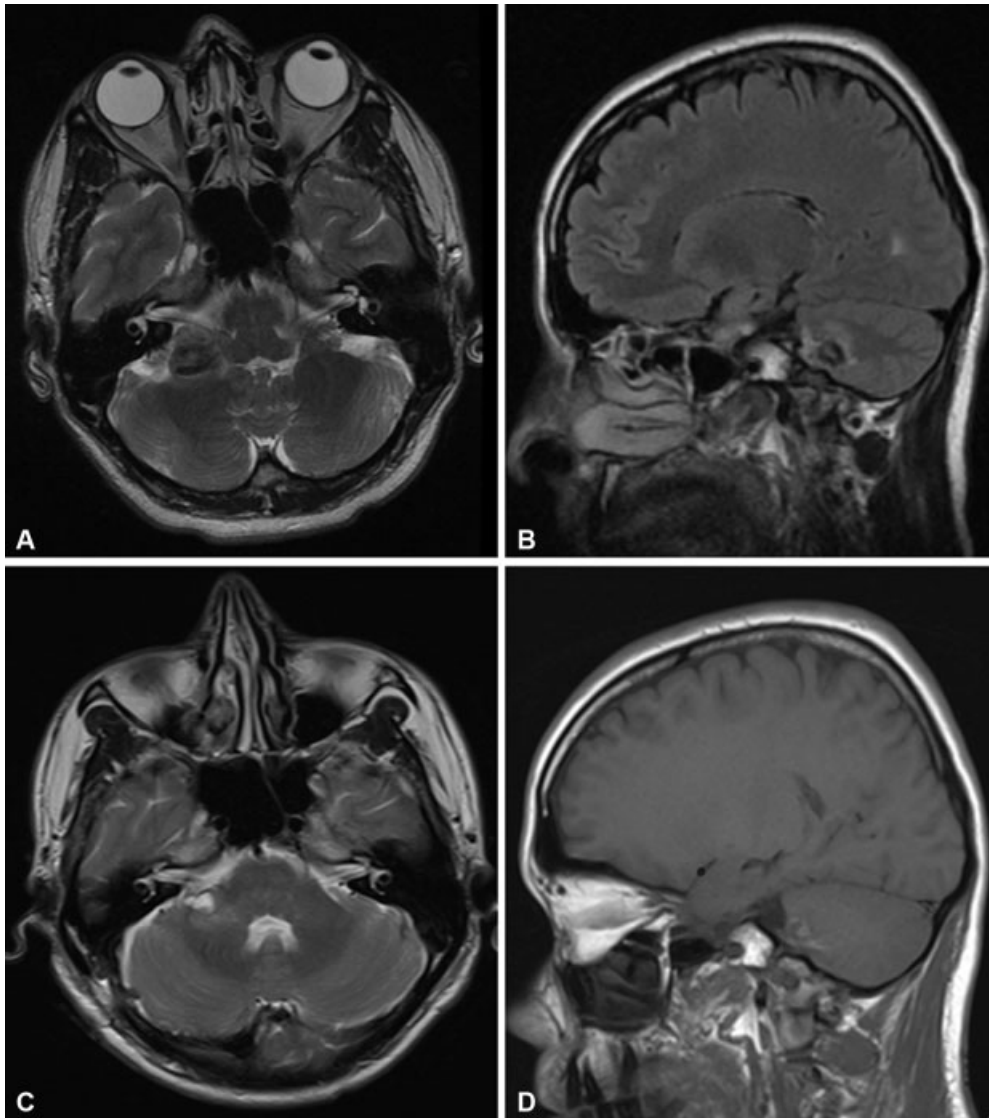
(A–B) Preoperative magnetic resonance images showing cerebellar peduncle lesion. The lesion was: (A) isointense on axial T2-weighted imaging, and (B) hypointense on sagittal FLAIR imaging. (C–D) Postoperative axial T2-weighted and sagittal T1-weighted magnetic resonance images showing gross total removal of the lesion with some residual blood in the surgical cavity.
